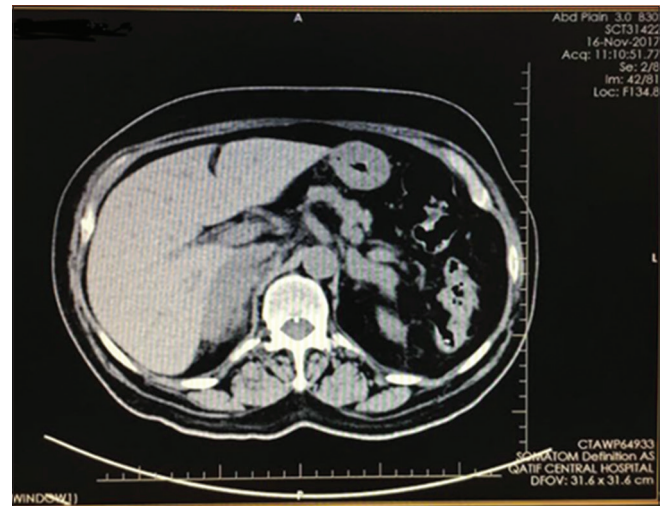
No contrasted adrenal computed tomography showing bilateral adrenal enlargement, and the areas are hypodense and maintain their overall shape
